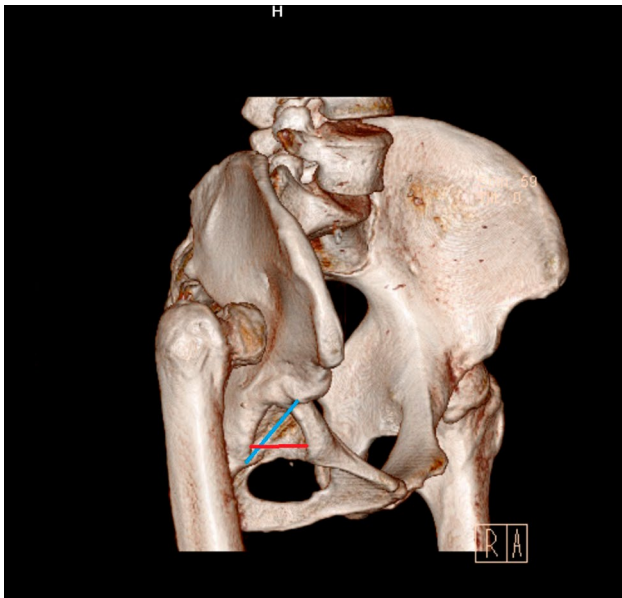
Oblique pelvis 3D pelvis CT. Red line shows axial diameter of true acetabulum. Blue line shows the length between ischium and SIAI
